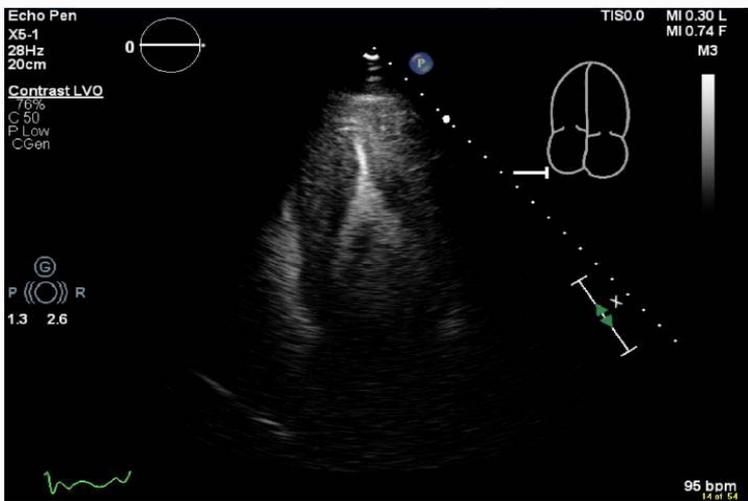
Showing apical four chambers with spade like appearance and severe apical hypertrophy.
